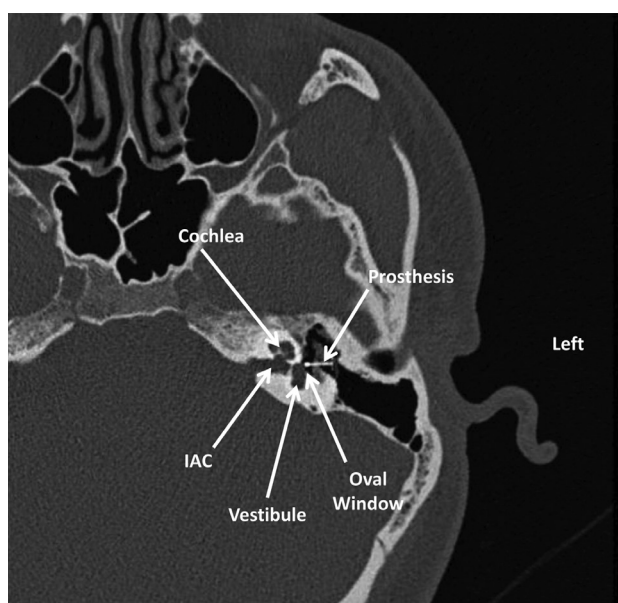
Axial CT image of the left temporal bones demonstrating the prosthesis that appears to span the tympanic membrane to the oval window.
